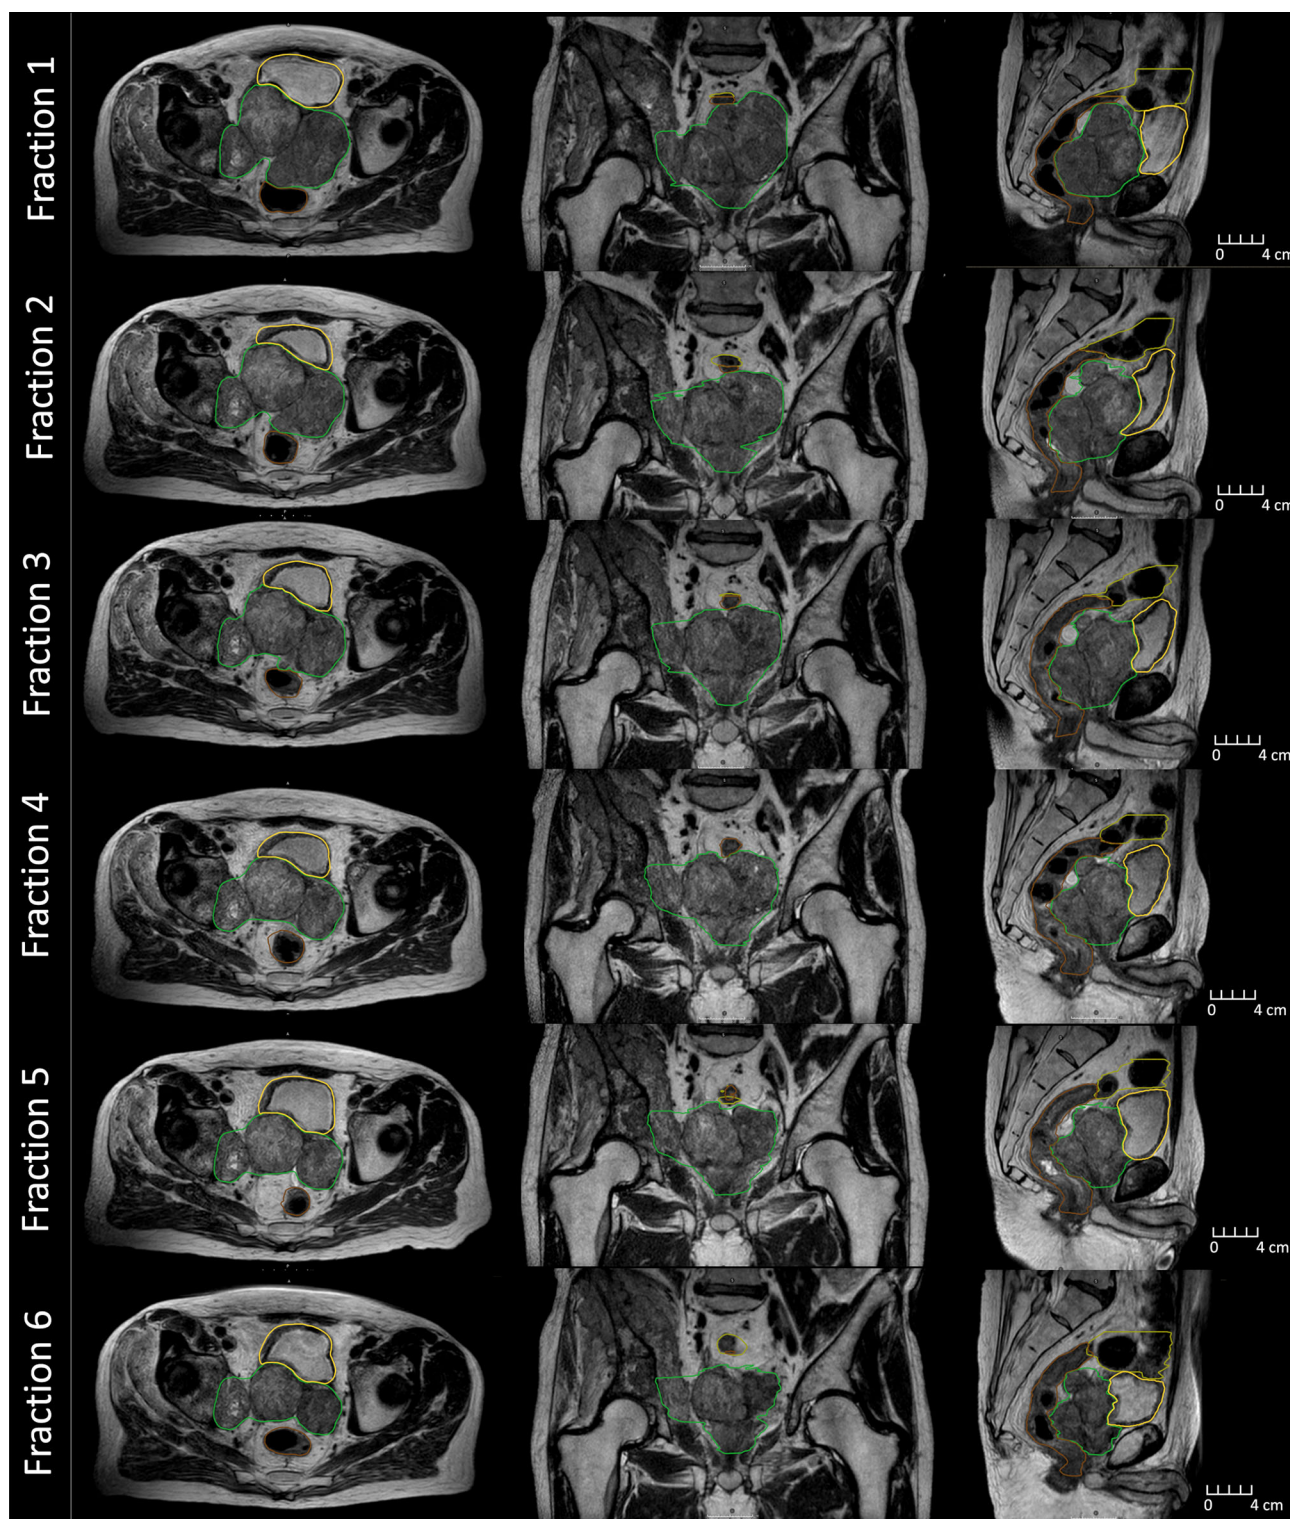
MR images collected during beam delivery for each fraction on the MR-Linac during treatment. Displayed is the clinical target volume (green), rectum (brown), bladder (yellow), and large bowel (olive).
